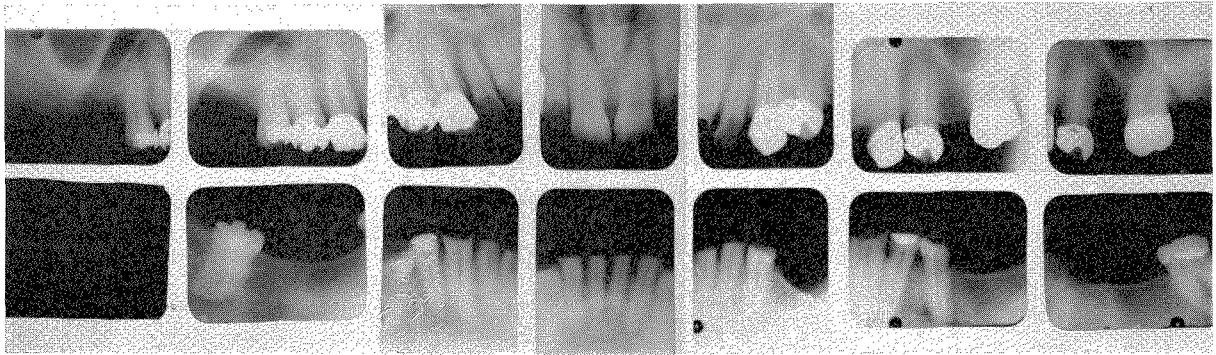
Roentgenograms taken in 1944 at the start of treatment. The oral structures were excellent.
